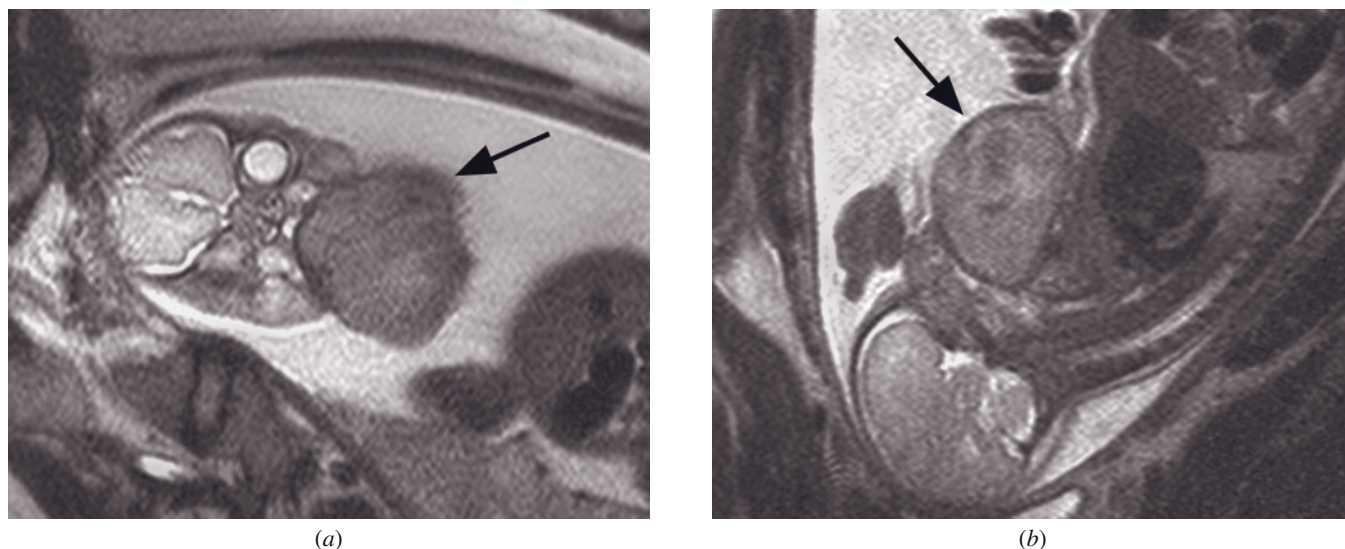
Teratoma of the fetal mouth. Coronal (*a*) and sagittal (*b*) T2-weighted SS-ETSE images through the fetal head and neck show a large, heterogeneous mass (arrow, *a, b*) arising from the fetal mouth.
